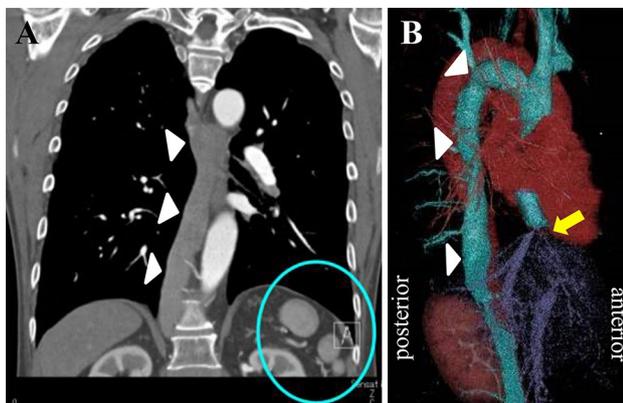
a Coronal view and b three-dimensional reconstruction of CT, showing that the IVC continued into the dilated azygos vein (arrowhead), which joined the superior vena cava (SVC). There were multiple spleens on the left side (blue circle). Three-dimensional reconstruction showed agenesis of the retro-hepatic IVC, and the hepatic vein drained directly into the right atrium (yellow arrow)
